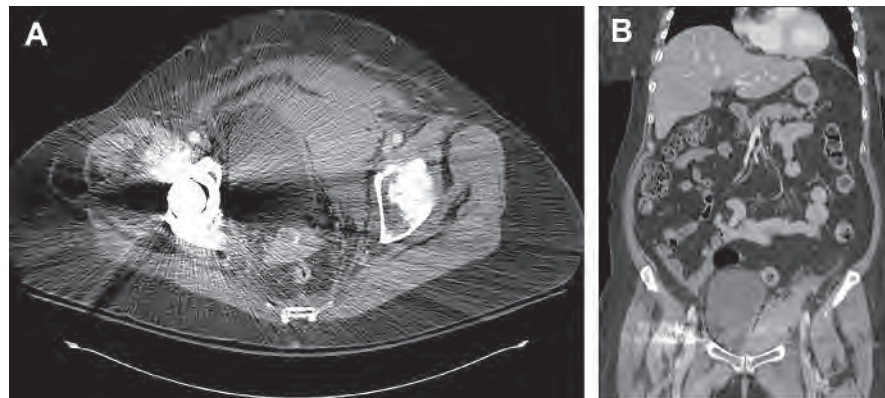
Retropubic hematoma formation following retropubic sling placement on (A) axial computed tomography imaging and (B) coronal computed tomography imaging.
